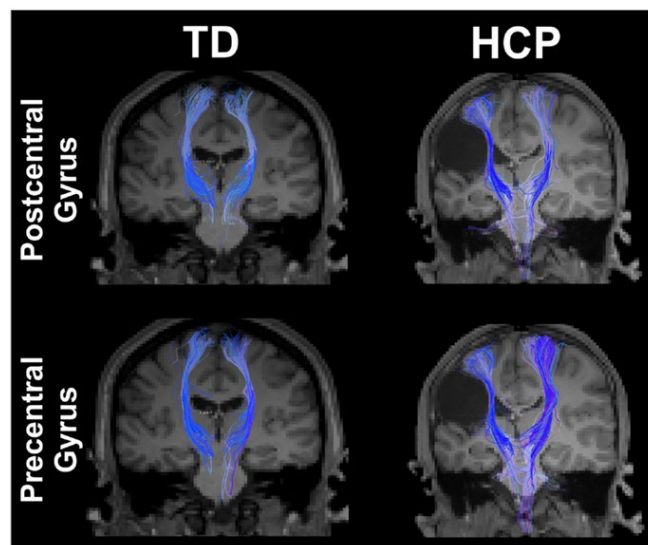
Thalamocortical white matter fiber tract projections in TD and HCP, patients captured via DTI and MRI imaging. Thalamocortical tract project to the primary somatosensory cortex. Adapted from 'Cortical somatosensory reorganization in children with spastic cerebral palsy: a multimodal neuroimaging study' by Papadelis et al., 2014, *Frontiers in Human Neuroscience*⁶
